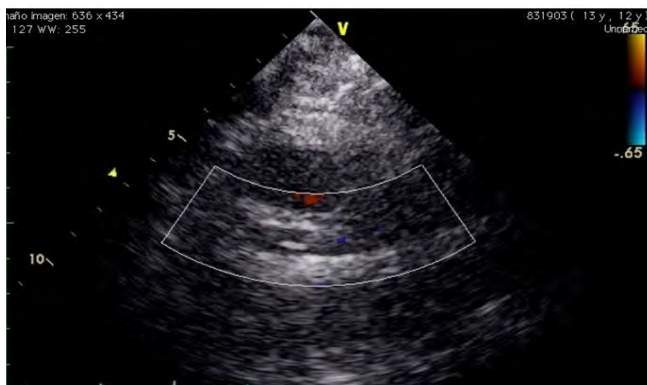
Doppler Color echography. A hyperechoic area is observed in the lumen of the right pulmonary artery corresponding to a thrombus that takes up more than 90% of lumen of the vessel.
